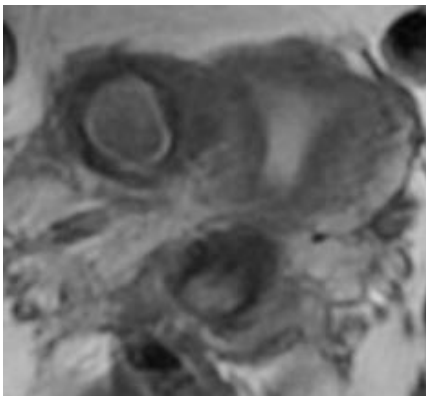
MRI image of ACUM in the right lateral myometrium
